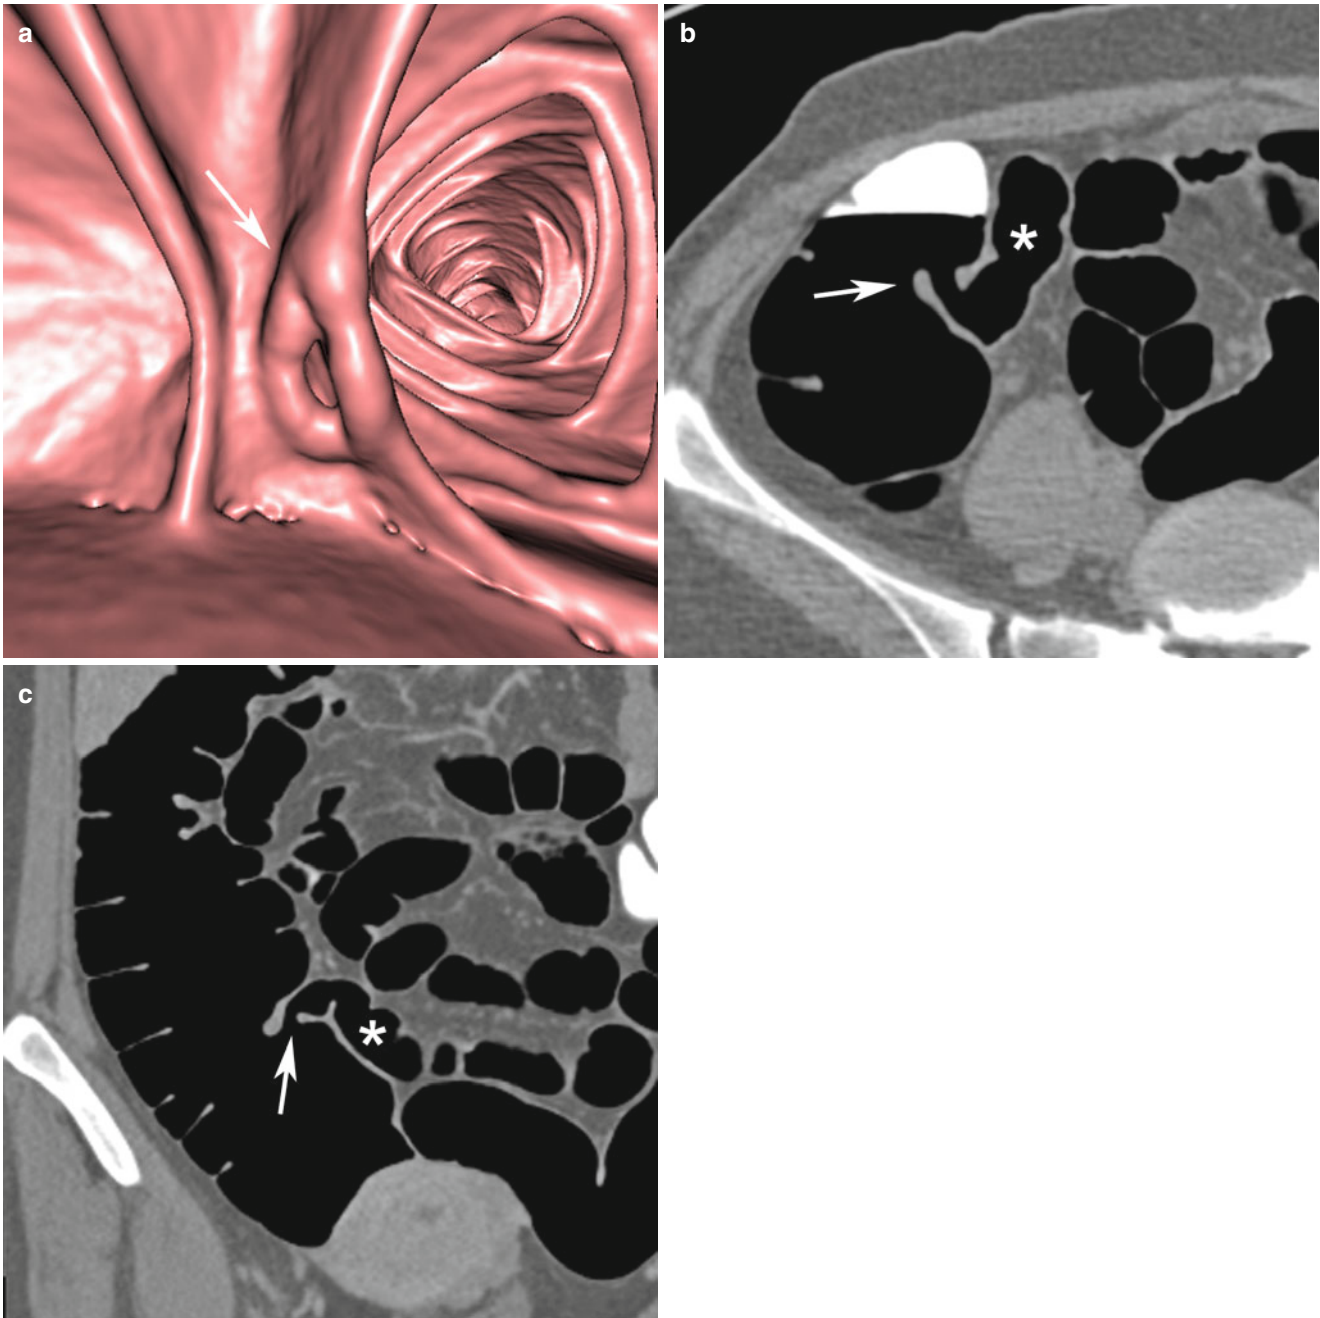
(a) Antegrade endoluminal 3D CT view from the cecum into the ascending colon, showing the ileocecal valve (*arrow*) with an upper and lower lip and, in between, the opened orifice. (b, c) Axial and coronal 2D CT image showing the blind-ending cecum in the right iliac
